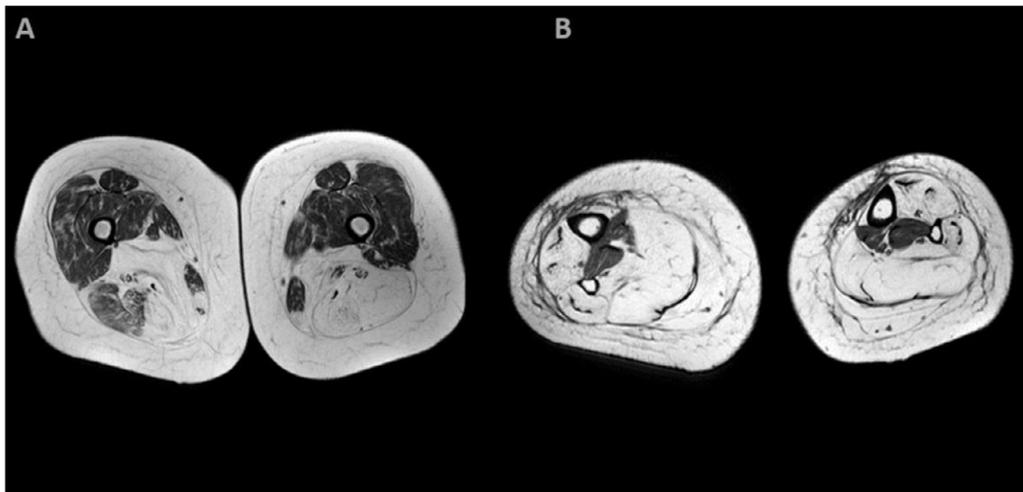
(A) Lower-limbs T1-weighted MRI of the thighs. Bilateral fatty infiltration of adductor and hamstring muscles is noted. Left thigh is slightly more affected. Quadriceps, sartorius and gracilis muscles are well spared for the age. (B) Lower-limbs T1-weighted MRI of the legs. Note the severe atrophy and fat substitution of almost every muscle. Tibialis posterior muscle and flexor digitorum longus are spared.
